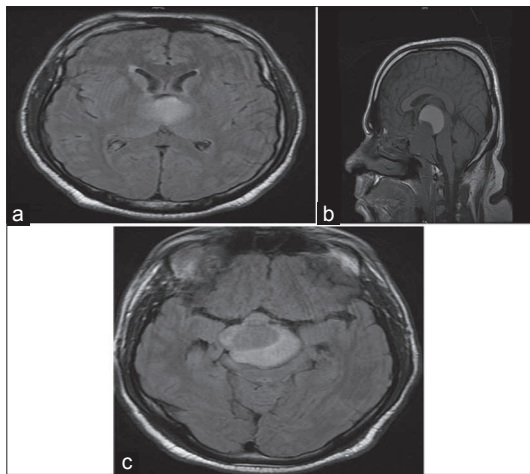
(a-c): Magnetic resonance imaging (MRI) brain showing pituitary macro adenoma compressing on the hypothalamus
